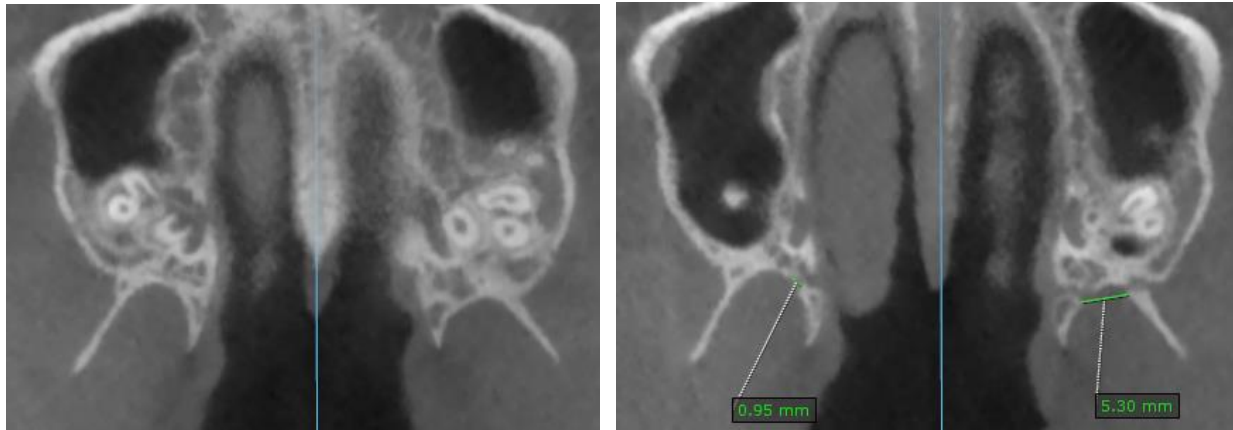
CBCT of a MSE patient. A: pre-expansion. B: post-expansion. Openings between the lateral and medial pterygoid plates detected on an axial slice situated between the axial palatal section (APS) and the lower nasal section (LNS) in the post-expansion CBCT.
